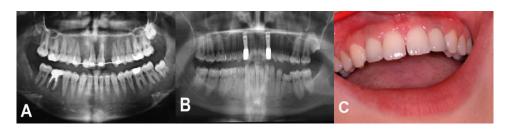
A. Panoramic radiograph before implant application. B. Panoramic radiograph after two implants placement. C. Frontal view of the definitive denture six years after implant placement [1].
